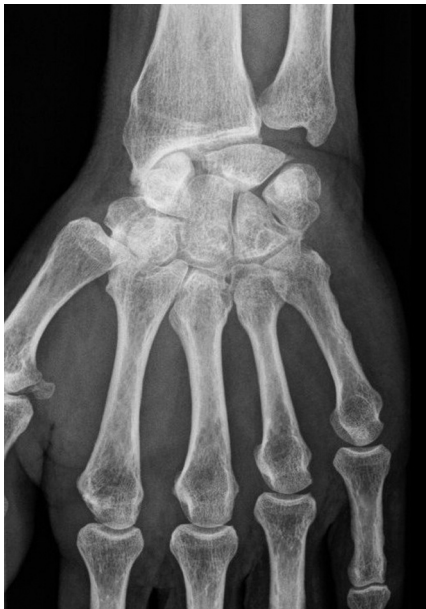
AP X-ray image of the right wrist.
